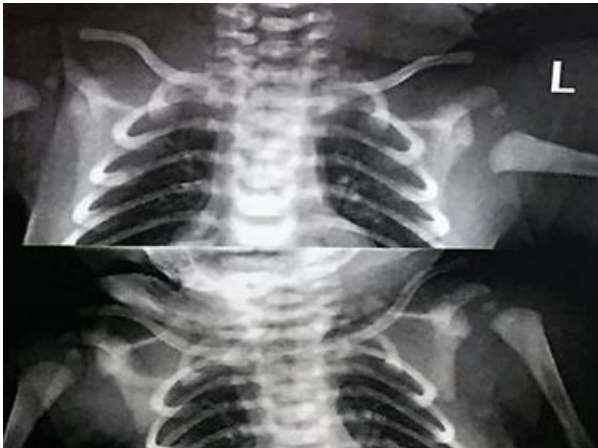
Diagnostic radiographs showing and displaced epiphysioly-sis.
